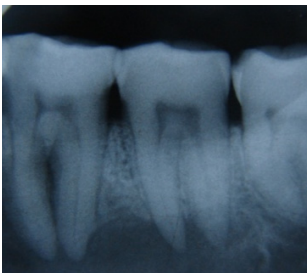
IOPA shows unilocular radiolucency at periapical area of 46, 47, with sclerotic border, Scalloping is seen at the roots of the teeth.
